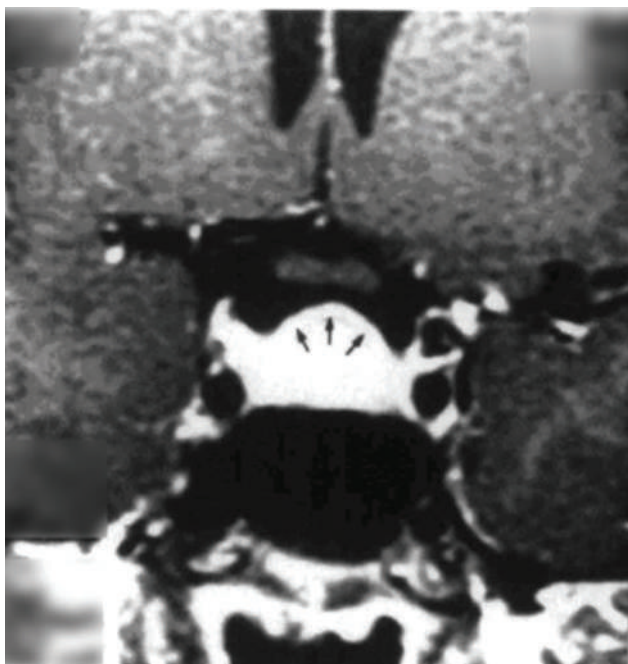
Coronal post contrast T1-weighted image depicting pituitary enlargement with characteristic dome shape (arrows) (used with permission).⁶
